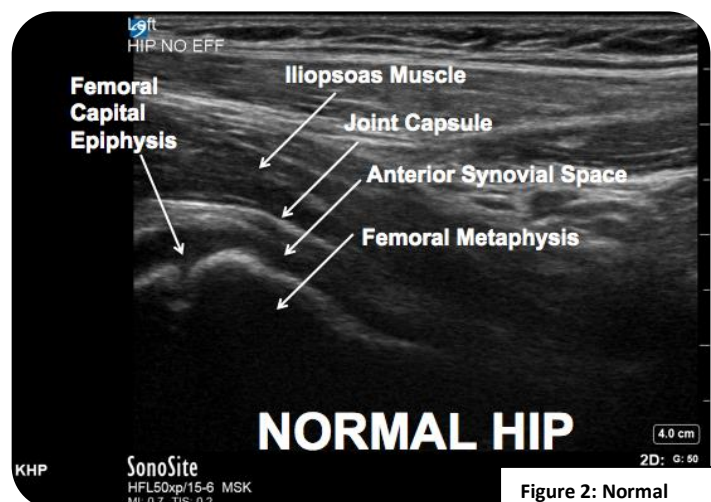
Normal Sonographic Anatomy of the Pediatric Hip
